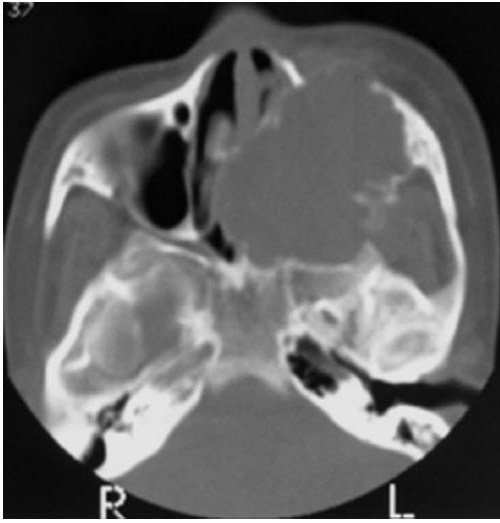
Axial CT (bone window settings) showing the tumor in the left side of the maxilla. The tumor obliterates the maxillary sinus and part of the nasal cavity. Note the scalloping nature of the growth of the tumor.
